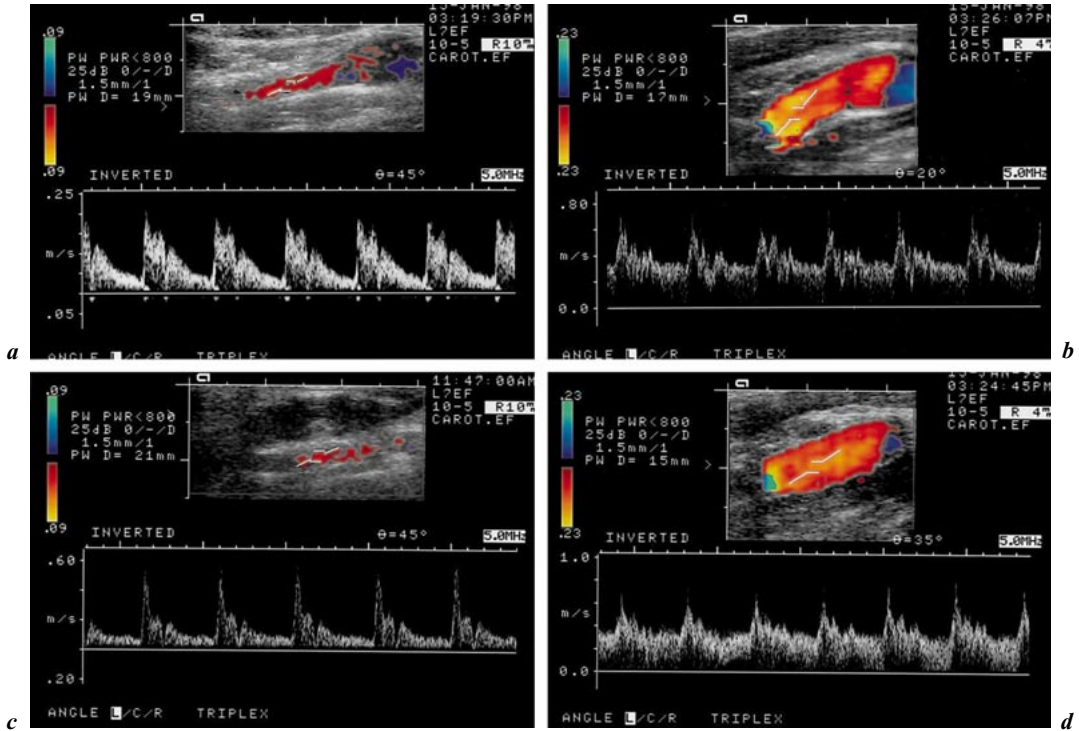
Extracranial color duplex sonography shows on the left side (*a*, *c*) the findings at the origin (*a*) and in the mid-cervical portion (*c*) of a spontaneously dissected internal carotid artery, and on the right side (*b*, *d*) the corresponding findings at the origin (*b*) and the mid-cervical portion (*d*) of the opposite normal internal carotid artery. The dissected carotid artery shows pathologically slow flow velocities affecting especially the diastolic component and a reduced luminal diameter compared to the normal vessel.
